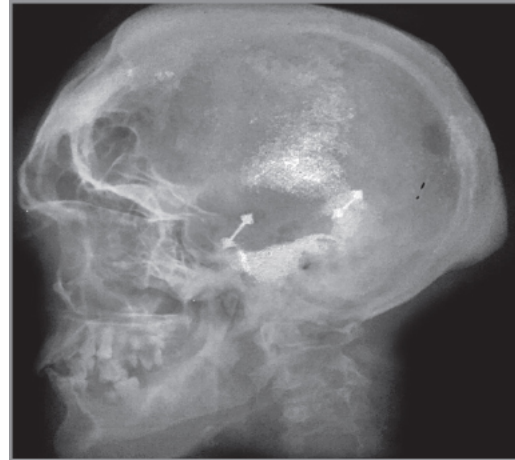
Lateral skull X-ray showing prognathism, thickened skull vault, prominent air sinuses, enlarged sella turcica—suggestive of acromegaly.
